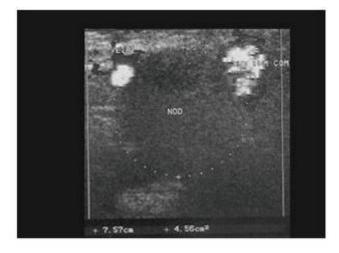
Color-flow venous Doppler ultrasound showing cystic mass in cross-sectional view, in left inguinal topography, showing compression of the common femoral vein
